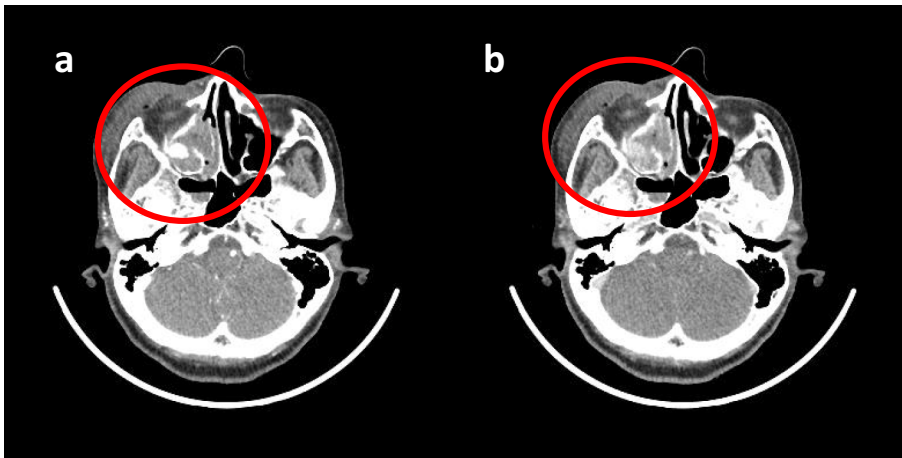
Contrast computed tomography at initial arrival (a: Arterial phase, b: Delayed phase). A right orbital fundus fracture, a right maxillary fracture, and extravasation detected (circle).
